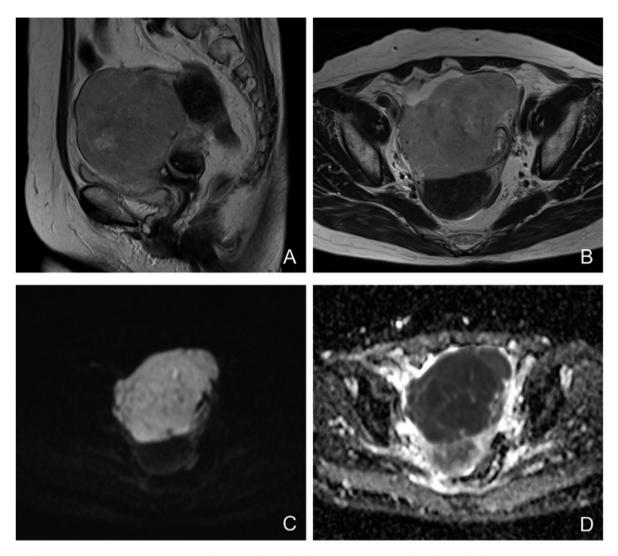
Pelvic magnetic resonance imaging revealing a mass located in the anterior uterine wall on T2-weighted imaging (A, B). A tumor showing high signal intensity on diffusion-weighted imaging (C) and low signal intensity on apparent diffusion coefficient mapping (D).
